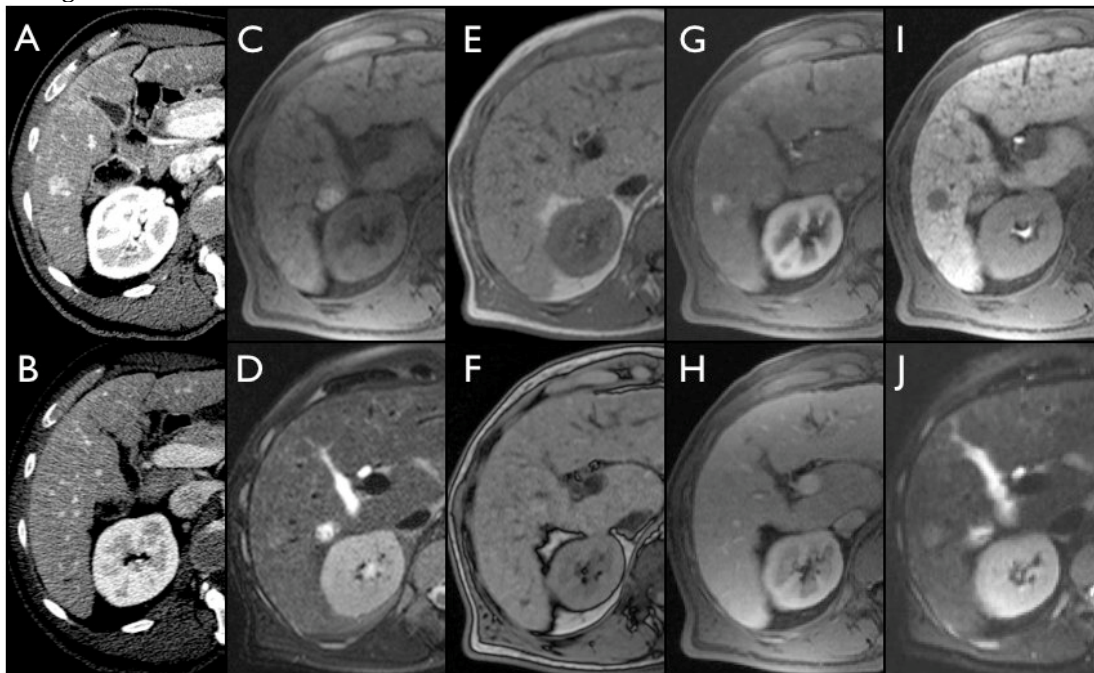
Example CT (A arterial, B portal venous phase) and MR (C precontrast, D T2, E in phase, F out of phase, G arterial, H portal venous phase, I hepatocyte phase, J diffusion) demonstrating a segment 6 arterial enhancing lesion which does not washout on portal venous phases, but does washout on hepatocyte phases consistent with a hepatocellular carcinoma (Grade 4), although on CT it appears to represent nodular arterial phase hyperenhancement (Grade 2).
